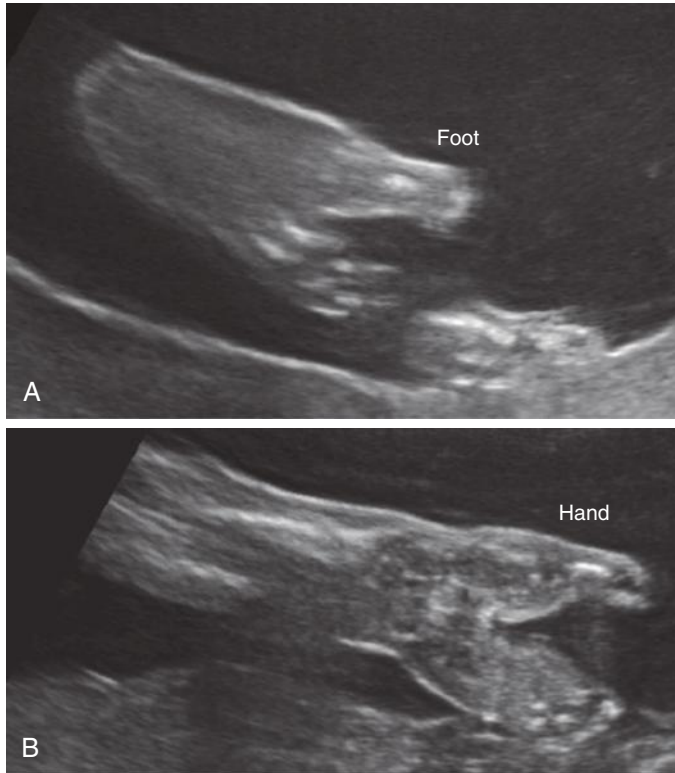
Ectrodactyly-ectodermal dysplasia-clefting (EEC) syndrome. Ectrodactyly of the lower (A) and upper (B) extremities. Sonographic findings of ectrodactyly, especially in association with cleft lip \pm palate, should prompt evaluation for EEC syndrome.
